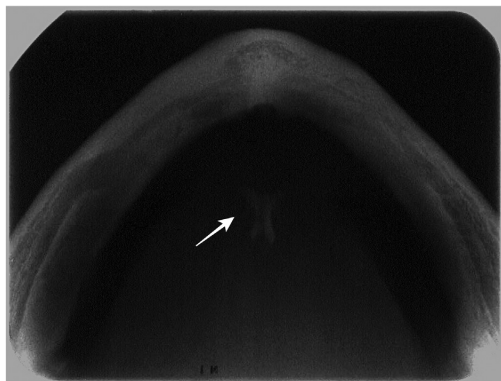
Occlusal radiograph of a 66-year-old woman showing a displaced genial tubercle bone fragment (arrow). The patient did not report a history of trauma.
